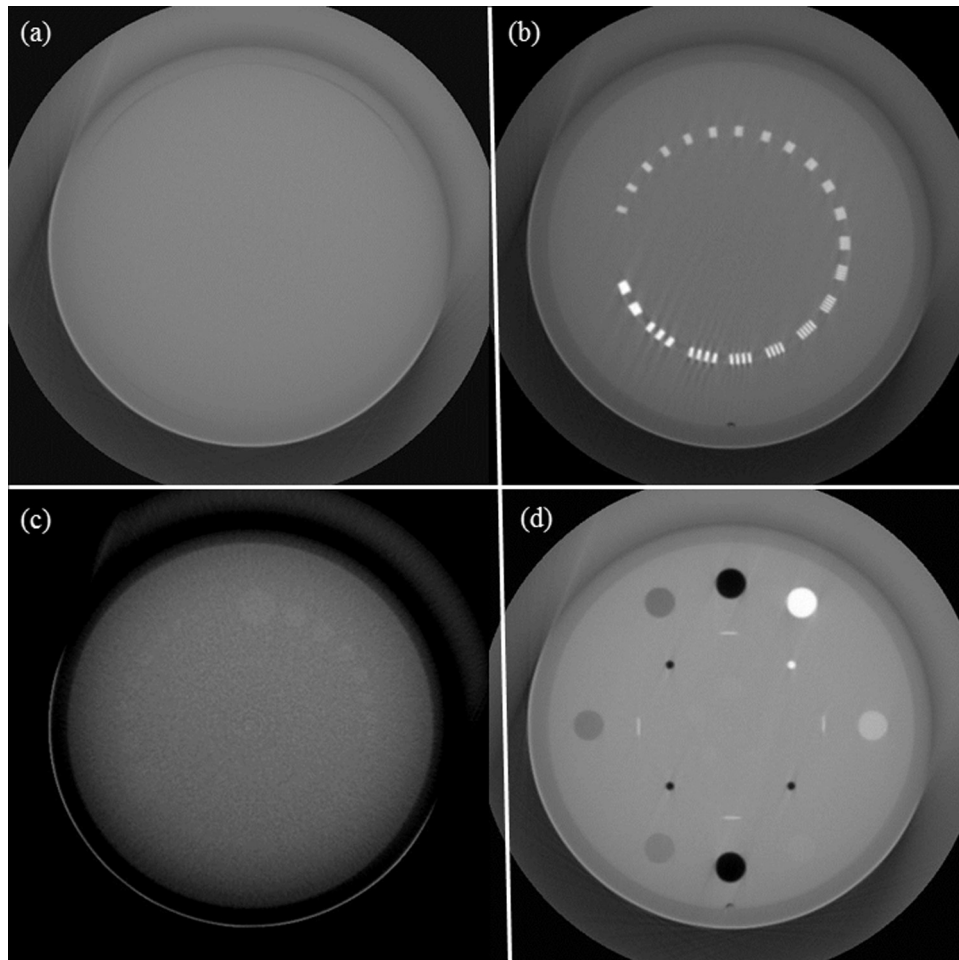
CBCT images of (a) image uniformity, (b) high-contrast resolution, (c) low-contrast resolution, and (d) Hounsfield Unit (HU) modules.
